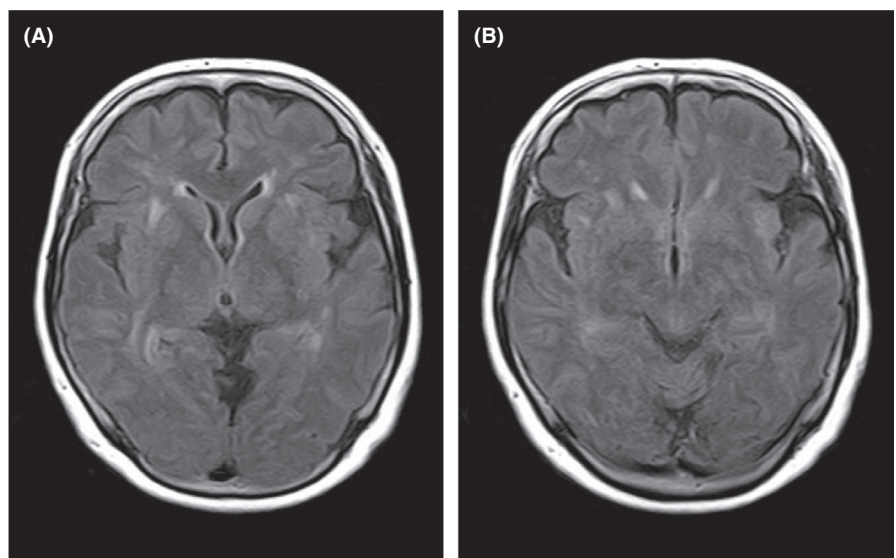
Axial Fluid Attenuated Inversion Recovery (FLAIR) MRI at the level of thalamus (A) and midbrain (B) showing no signal abnormalities
